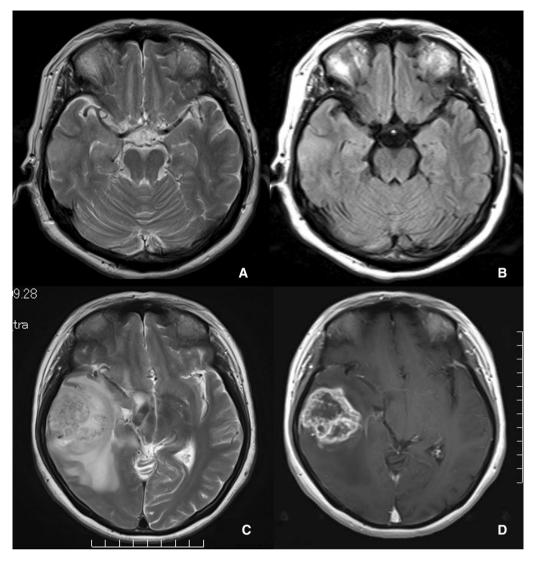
Case 5. a Axial T2-weighted MRI showed no abnormal signal intensity. b An axial fluid-attenuated inversion recovery (FLAIR) image showed a very slightly hyperintense and poorly demarcated lesion without a mass effect in the right temporal lobe. c At
